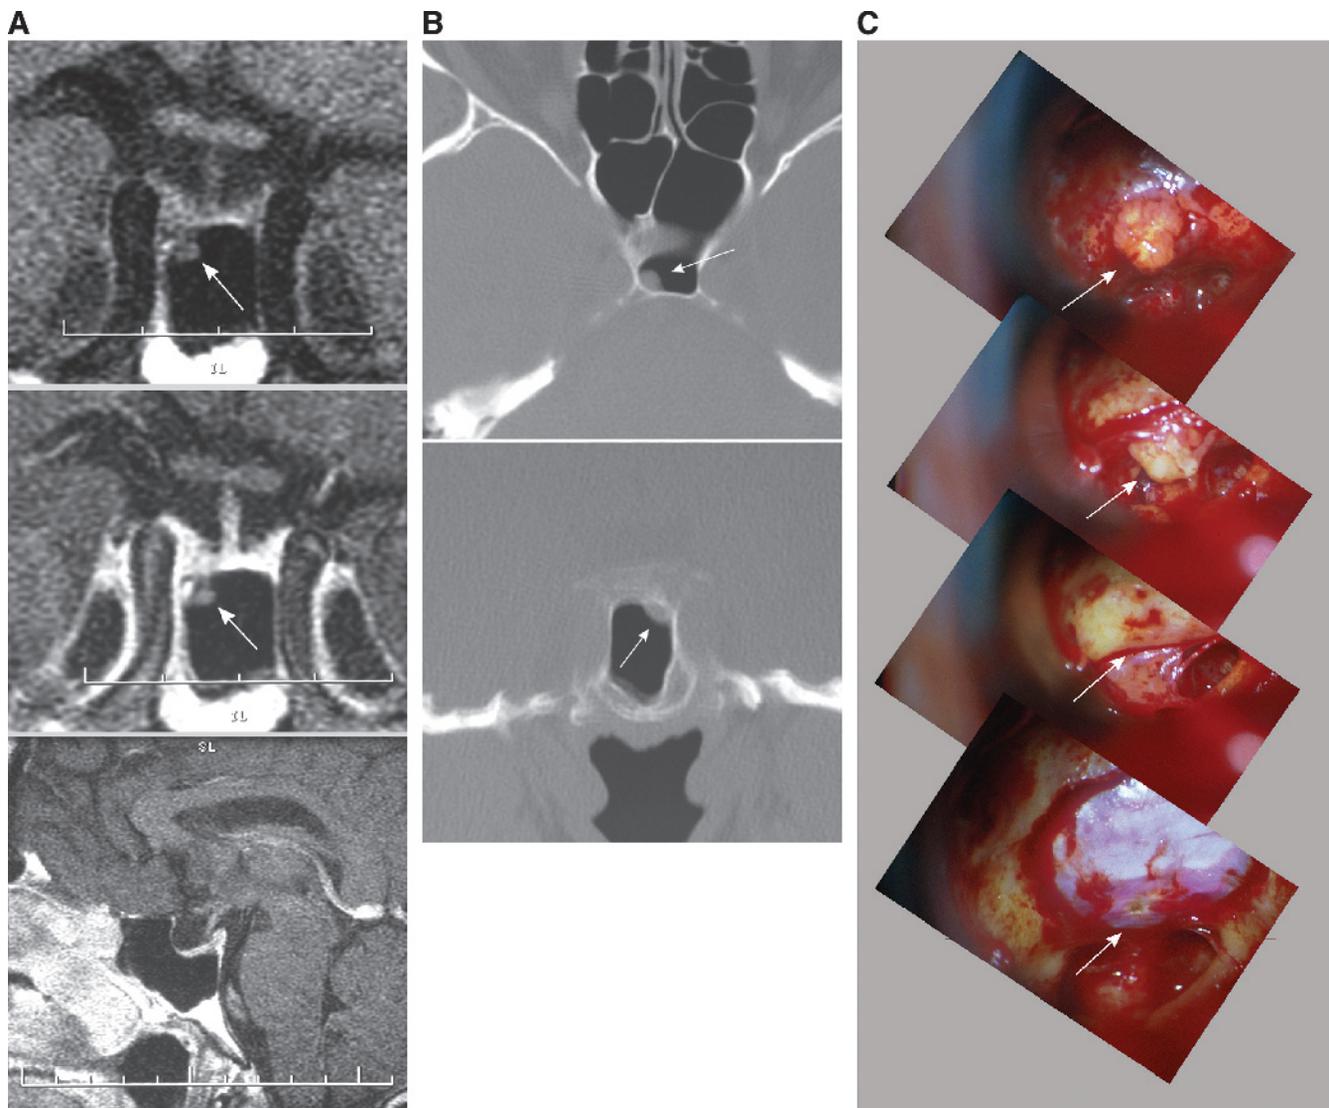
A, pituitary MRI before (upper) and after (middle, bottom) contrast enhancement. Note the adenoma in the sphenoid mucosa (arrows) and that the ectopic adenoma is associated with an empty sella syndrome (bottom). B, computed tomography shows that the bone of the sella floor is intact, as is also seen at surgery. C, the series of operative images, taken in sequence from top to bottom during exposure and removal of the tumor, show the intact tumor in the sphenoid mucosa (top 2 images), that the tumor was outside the bone (the sella face and floor are shown intact in the third image from the top), and that the dura is also intact in that region of the sella (bottom).
